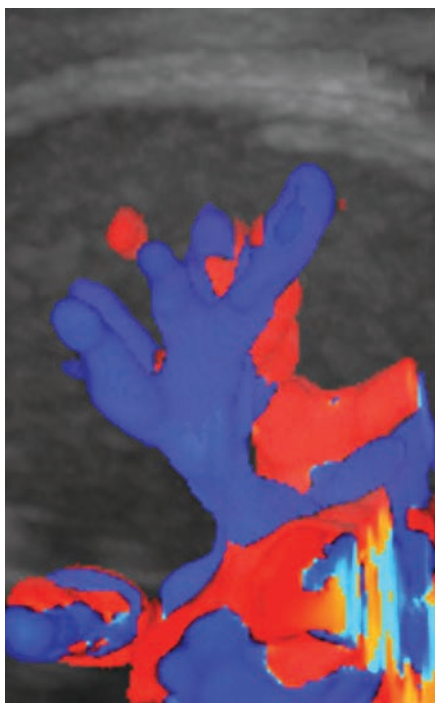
Pulmonary veins and arteries are demonstrated with 3D color Doppler ultrasound.
